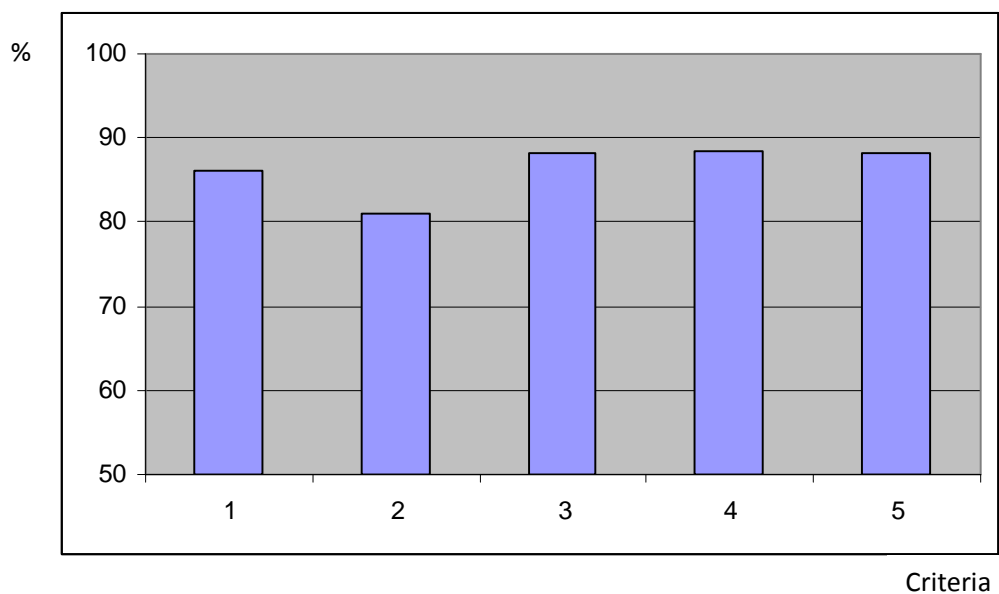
Performance percentage of the image quality criteria for Spine X-ray in Lateral Projection
